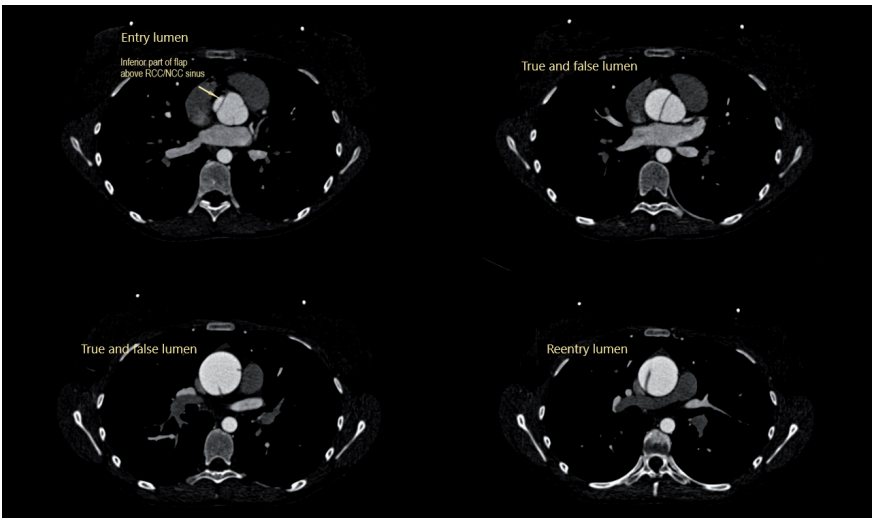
CTA – axial scan showing aneurysm dilation of ascending aorta with flap contour
